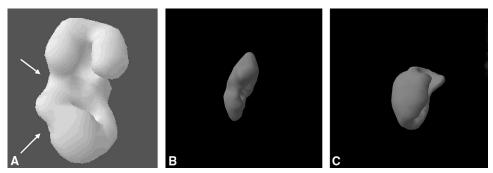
99mTc-DMSA SPECT scans showing: (A) focal cortical defects (arrowed) consistent with scarring in a patient with late recurrent urinary tract infections; (B) cortical irregularity in a patient with chronic allograft nephropathy; and (C) an upper pole segmental defect in a patient with occlusion of a polar artery.
